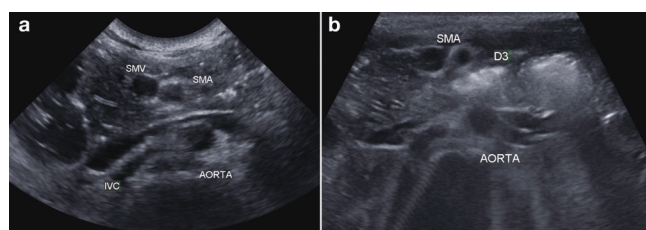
Abdominal ultrasound. (a) The SMV and the SMA are normal in relationship. (b) The D3 crosses from right to left between the abdominal aorta and the SMA when clear fluid was administered.
